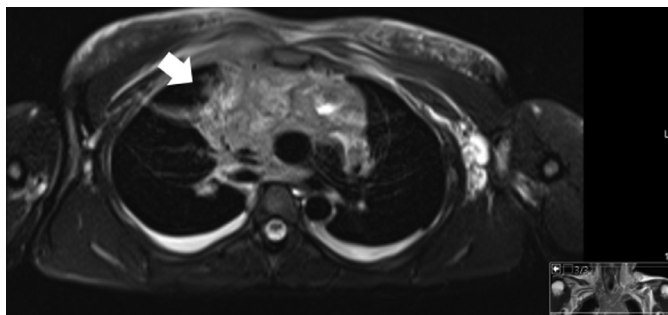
A gross mediastinal mass fully embedding the SVC (transversal T2 MRI).
